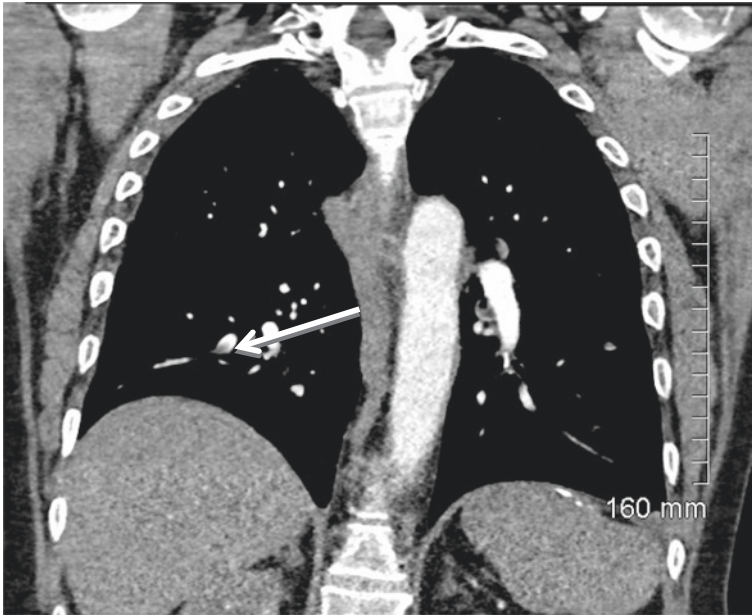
This is a coronal reformat of a CT Pulmonary angiogram performed in a 26-year old patient presenting with pleuritic chest pain. The patient reported a history of taking the oral contraceptive pill. This study showed an embolus in a segmental branch of the right lower lobar pulmonary artery, denoted by the white arrow
